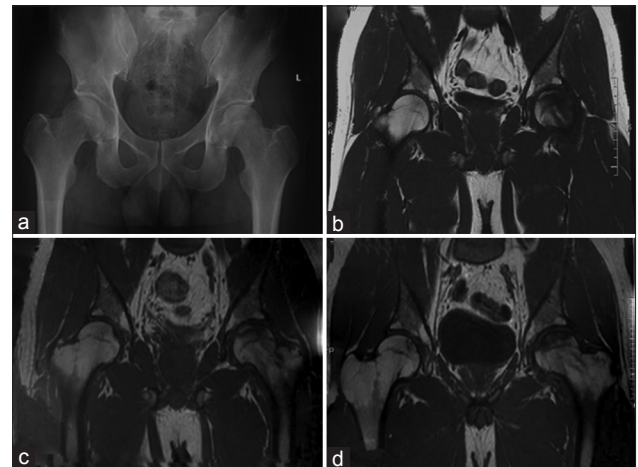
Images of a 36-year-old male. (a) A preoperative radiograph and (b) MR image showed AVNFH in the left femoral head; (c and d) MR image is respectively 17 months and 38 months after the surgery showed there were not obvious deteriorate AVNFH compared with the preoperative radiograph and MRI. AVNFH: Avascular necrosis of femoral head; MRI: Magnetic resonance imaging; MR: Magnetic resonance.
